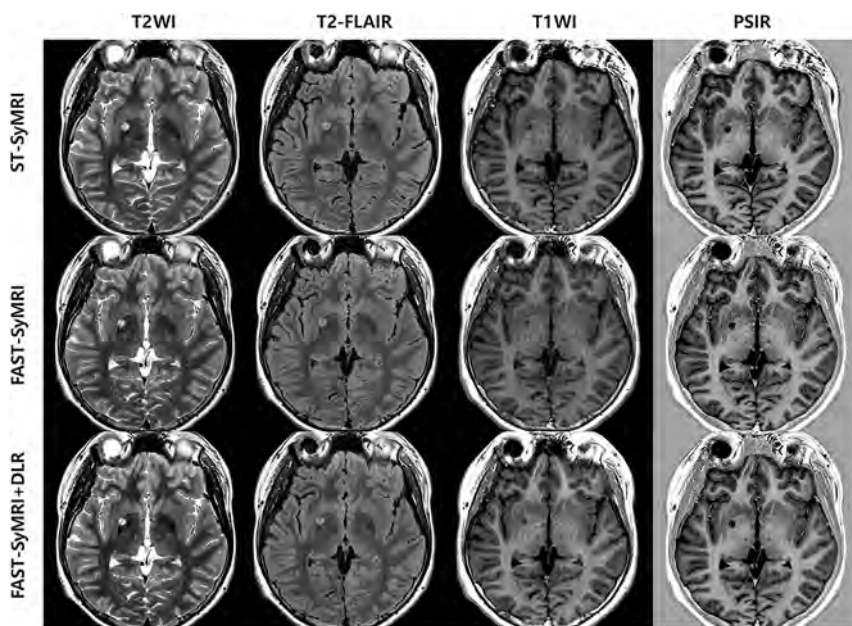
Axial contrast-weighted images of a 14-year-old boy who underwent brain MR imaging due to abnormal movement. By applying DLR, the overall image quality and image artifacts of the FAST-SyMRI appear significantly improved for all contrast-weighted images. FAST-SyMRI+DLR images show comparable or superior overall image quality relative to ST-SyMRI images. No significant difference is noted in lesion detectability between the FAST-SyMRI+DLR and the other 2 MR imaging protocols.
